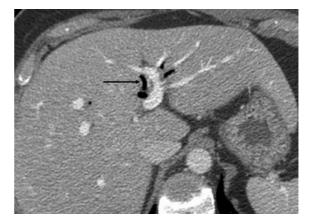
Contrast-enhanced CT scan after biliary-enteric anastomosis demonstrating pneumobilia in the left bile ducts (*arrow*)
